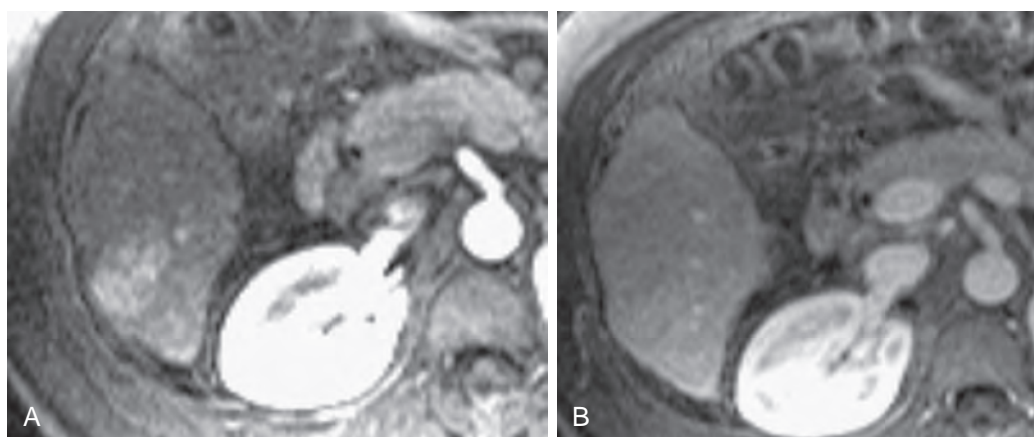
HCC: the importance of hepatic arterial phase imaging on MRI. The tumor enhances during the hepatic arterial phase (A) and becomes isodense with the adjacent parenchyma during the portal venous phase (B). Thus this lesion would not be detected if scans were obtained only during the portal venous phase.
